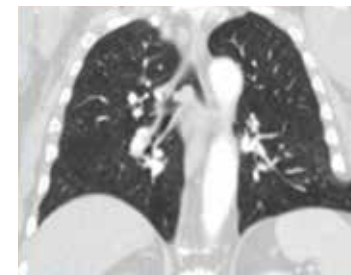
Coronal view of the chest CT scan showing near complete obstruction of the right main stem bronchus.
